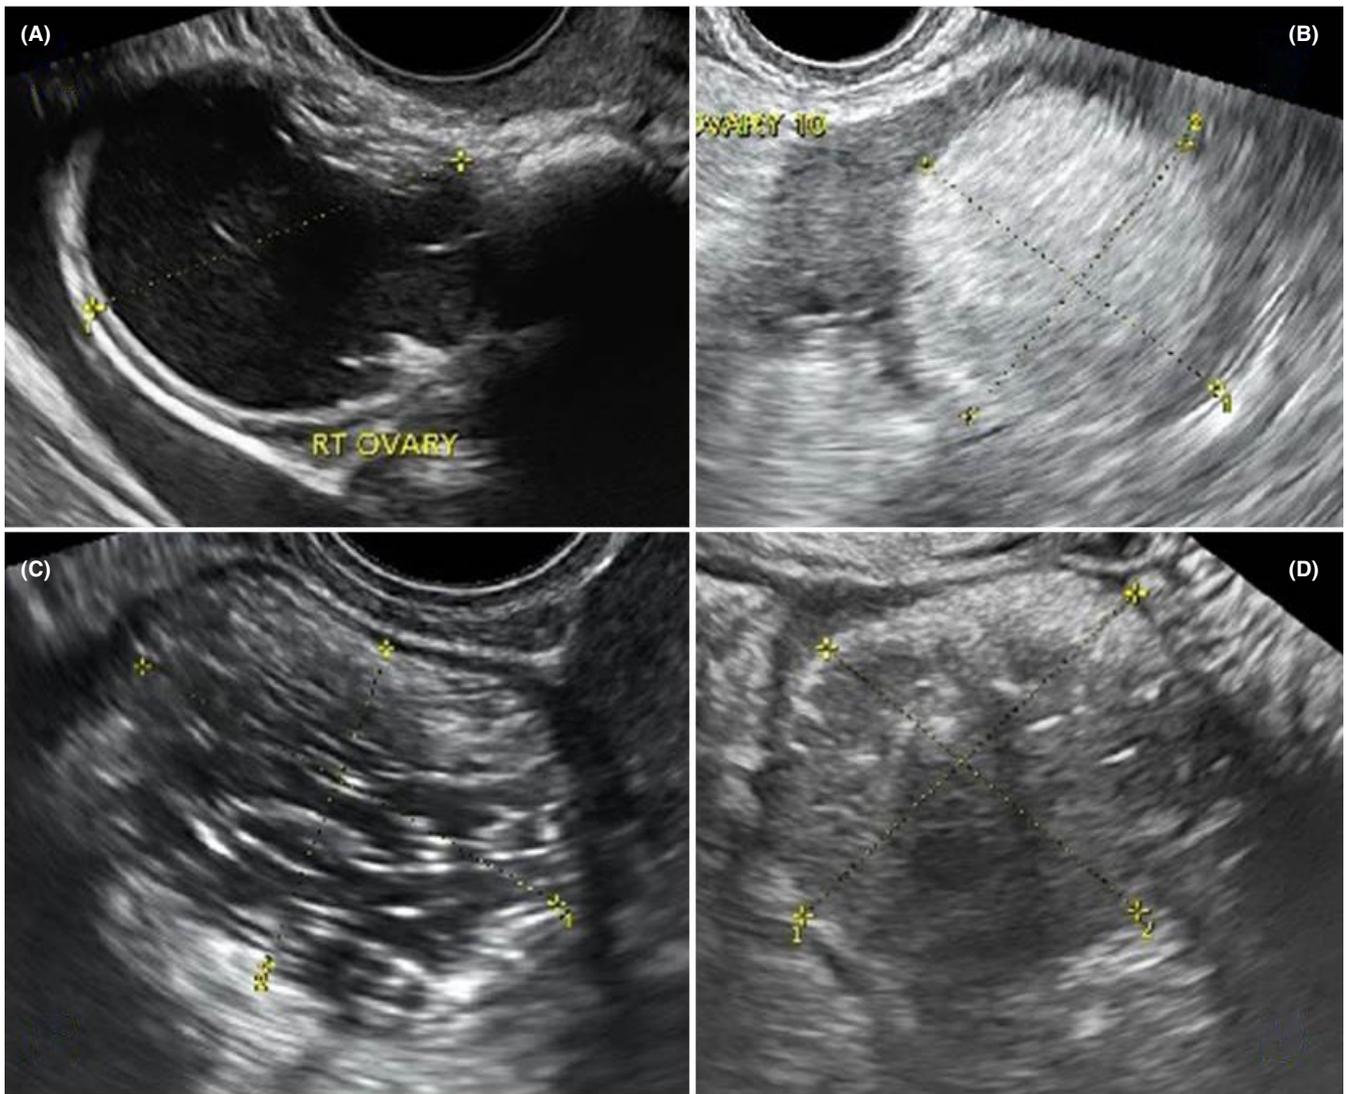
Different ultrasonographic features of a dermoid cyst. (A) Cystic adnexal unilocular mass with a “Rokitansky Nodule” on the superior margin. (B) Finely delimited dermoid plug and dermoid mesh created by different echogenic structures. (C & D) Adnexal masses with mixed echogenicity, dermoid mesh sign, multiple calcifications and posterior acoustic shadowing.
